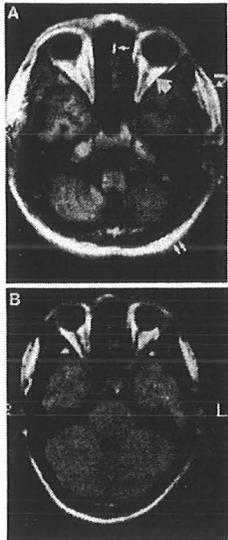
A. Axial MRI through orbits in a patient with CGL showing presence of fat in the orbits (arrow head), temporal region (curved arrow), crista galli (small arrow), and subcutaneous area of scalp (double arrows). B. Similar image from a normal volunteer showing normal distribution of fat in the orbits, temporal region, and subcutaneous area of scalp.
